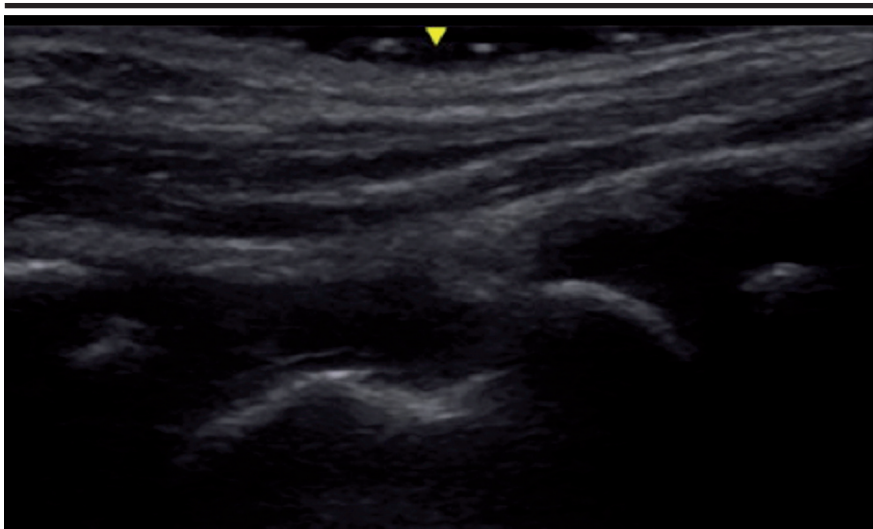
Musculoskeletal ultrasound image of an ankle of 4 years-old girl. Longitudinal scan of the anterior recess, showing tibio-talar synovitis.
